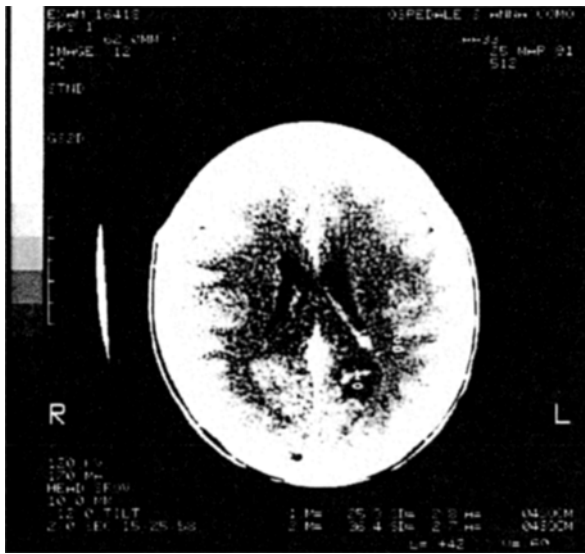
Computed tomographic scan shows two low-density areas, one in the left parieto-occipital hemisphere and one in the left thalamus
